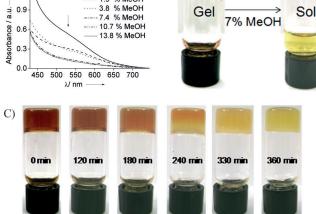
Gelation promoted by simultaneous hydrogen bonding and CT interactions.
